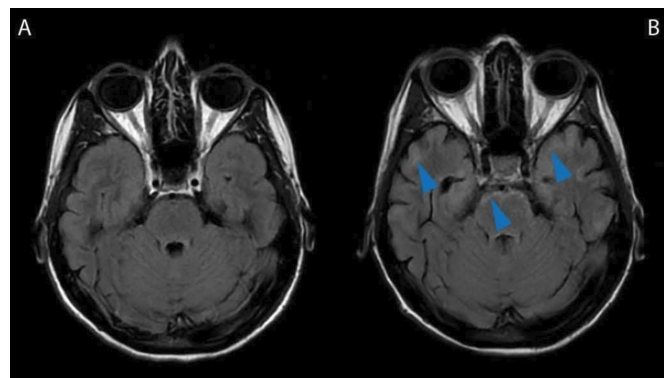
(A) Axial fluid-attenuated inversion recovery MRI of the head at baseline, showing no abnormalities. (B) Axial fluid-attenuated inversion recovery MRI at admission showing bilateral subcortical hyperintensity in the temporal lobes and a thin-rimmed hyperintensity in the pons (blue arrowheads).
